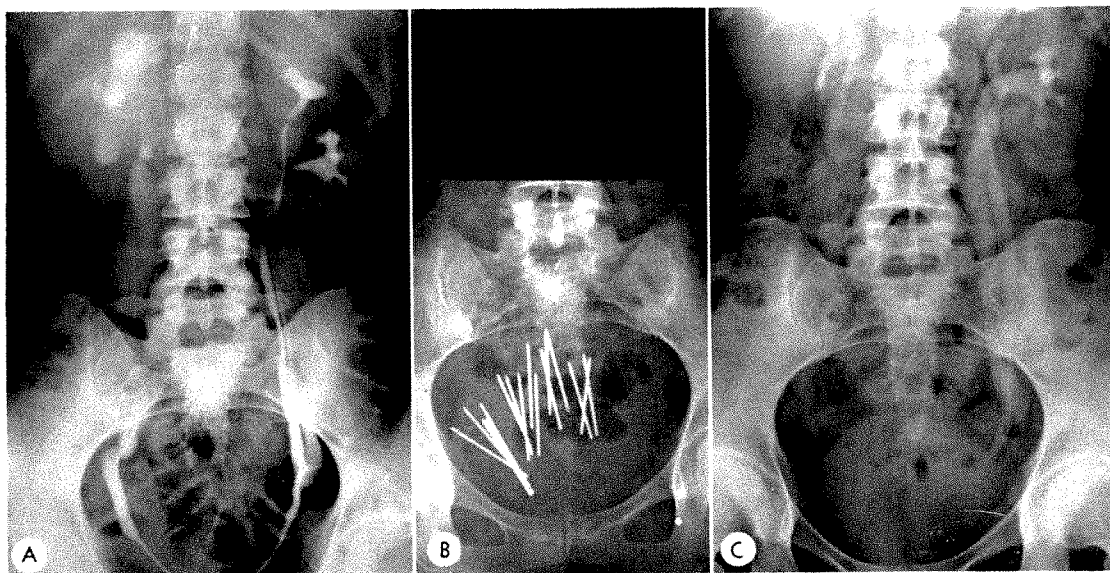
Case IV. (A, B and C) Hydronephrosis and dilatation of the right ureter secondary to malignant invasion of the right parametrium was relieved in 4 months by the implantation of low intensity radium needles in a cancer of the cervix and the right parametrium for 7 days, with the addition of a small amount of conventional roentgen therapy.
